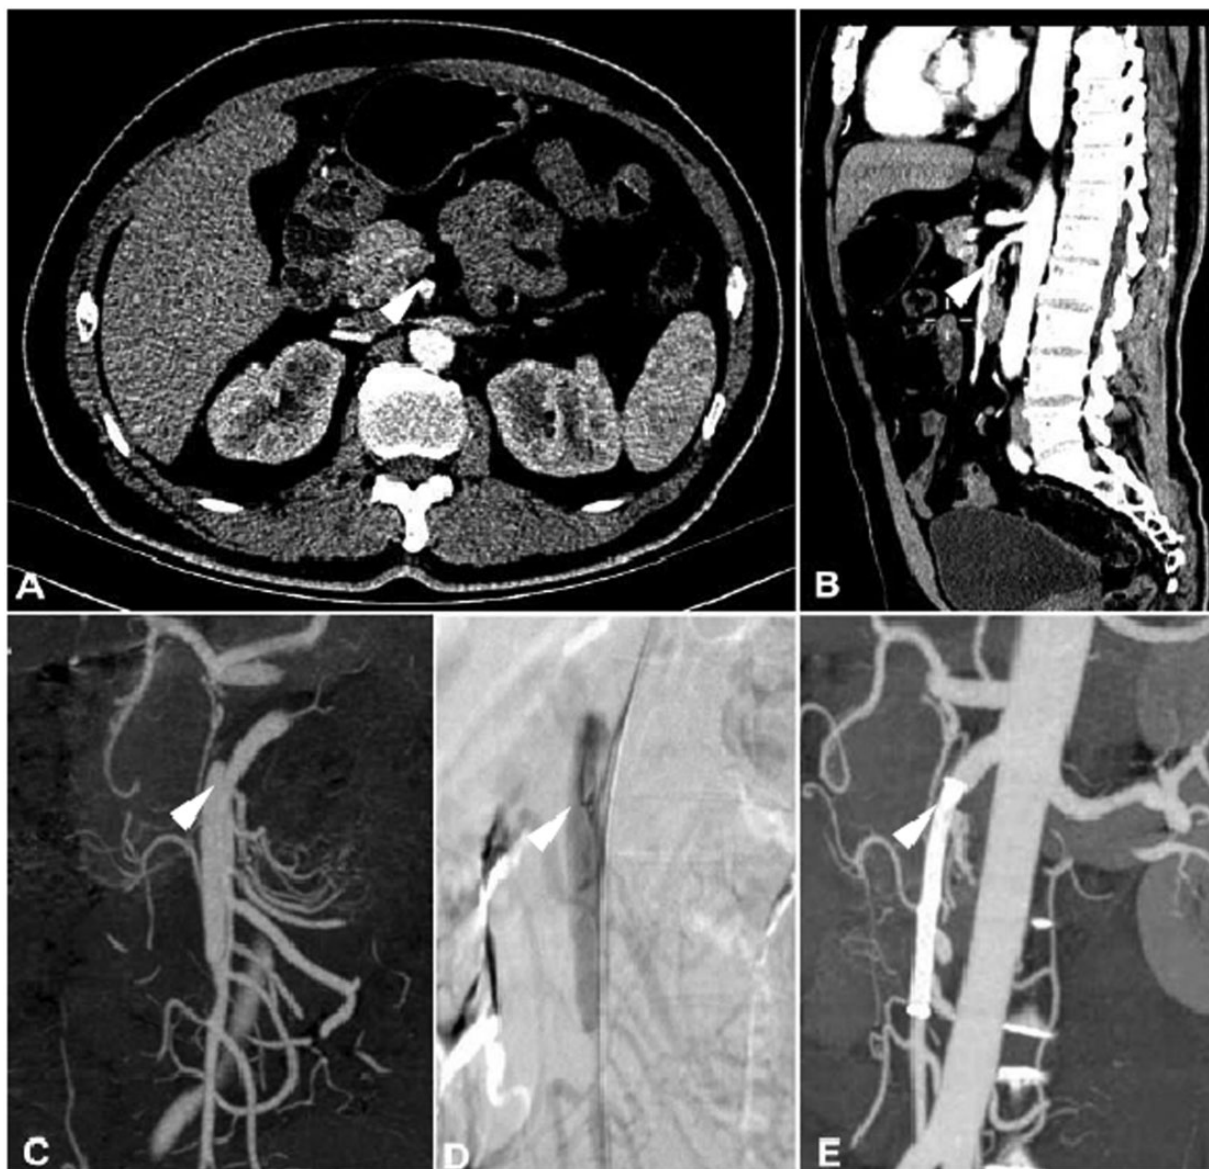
Example of failed conservative management of a symptomatic ISMAD with development of negative morphological changes (TLRD worsening). A 53 years old man presented with acute abdominal pain that had lasted for 3 h. Contrast enhanced CT scan showed a ISMAD (type IIa) (a and b, arrow). Abdominal pain worsened after 3 days of conservative management and superior mesenteric angiography revealed true lumen compression severely (c and d, arrow). Subsequently, two self-expanding bare stent were performed in the segment of the lesion (e, arrow).
